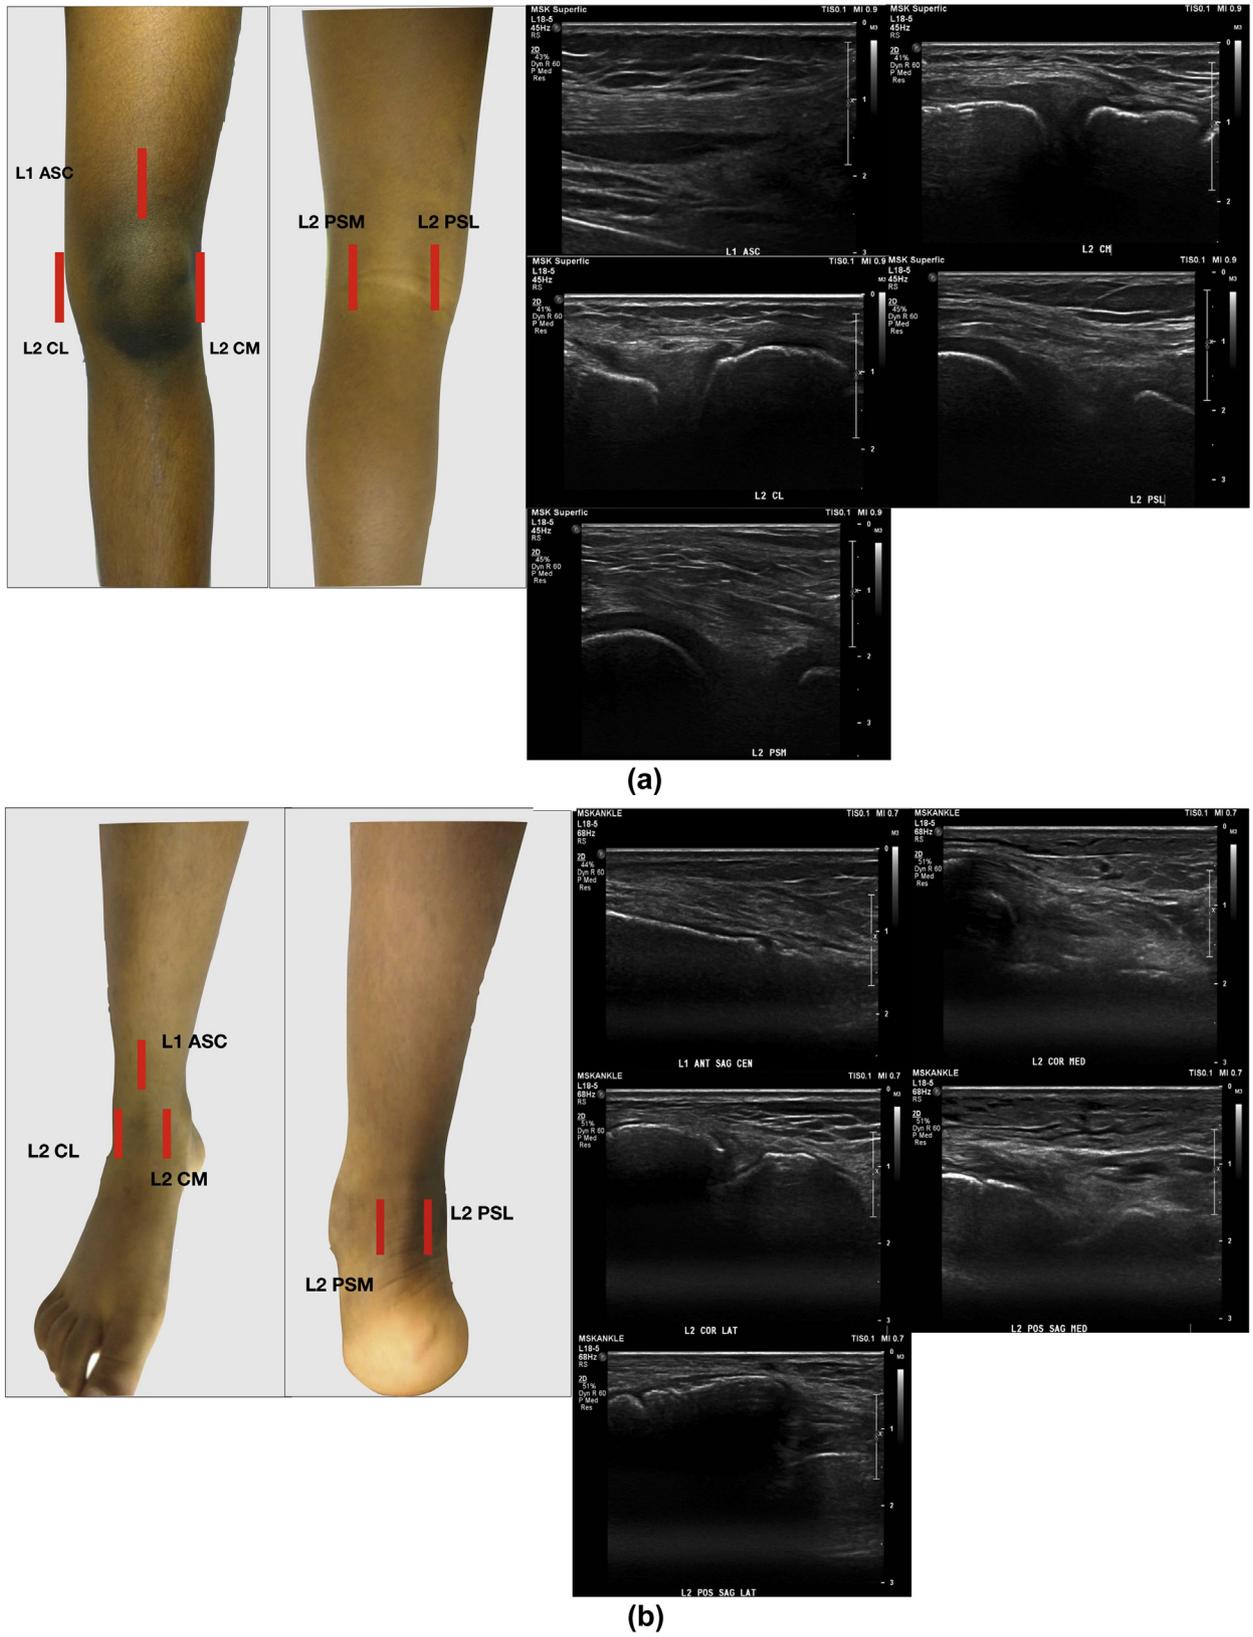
(a) Frontal and posterior views of the right knee and (b) of the right ankle with rectangular boxes (red coloured) representing the footplate of the ultrasound probe in standard views of the US-US protocol with the representative ultrasound images. L1 is above the level of the joint and L2 is at the level of the joint.
